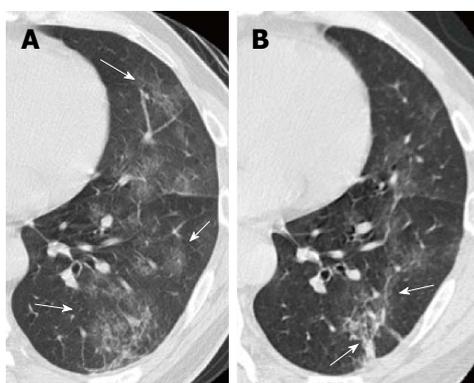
Pneumonia caused by aspiration of gastric fluid in a man in his 50s. A: Initial thin-section computed tomography (CT) shows patchy ground-glass opacity in the left lung with reticulations; B: Thin-section CT 2 d later demonstrates partly increased attenuation with concave margin of the opacities as well as a general resolution of pneumonia.
